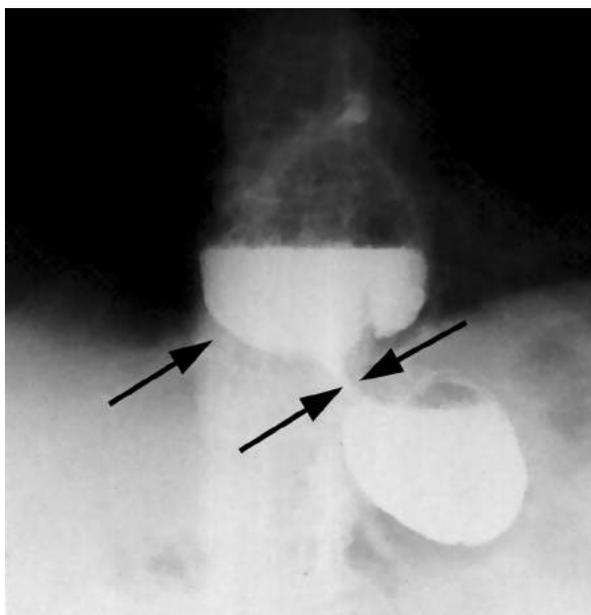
Post - corrosive stricture in the cardiac region, with consequent dilatation of the lower third part of the oesophagus (oesophageal contrast radiography, from the collection of the author)
